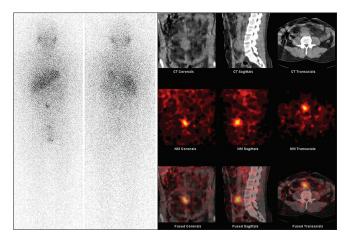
A 33-year-old male presented with abdominal pain and headache. Urinary metanephrines were elevated. Computerized tomography (CT) scan showed soft tissue density mass at the aortic bifurcation (organ of Zuckerkandl). Iodine-131 metaiodobenzyl guanidine (MIBG) whole body scintigraphy and single photon emission computed tomography/CT showed MIBG avid lesion in a soft tissue lesion at the level of L3-L4 vertebrae. Surgical removal was done and the mass proved to be paraganglioma
